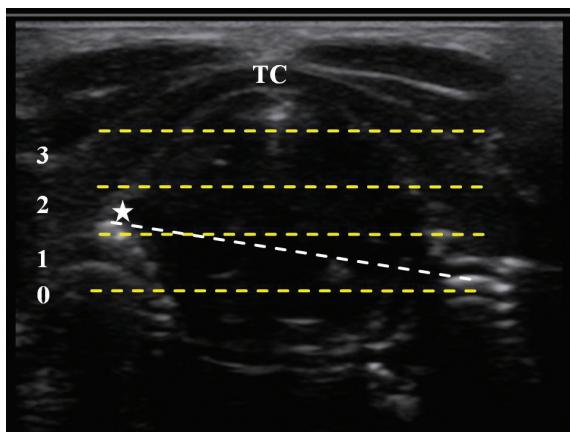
Transverse sonogram of the glottis. The asymmetrical elevation of an arytenoid cartilage was scored from 0 (bilateral symmetrical arytenoids) to 3 (in the upper one-third range of) in the reference to the dashed sections between the anterior and posterior commissures. The star* indicates the arytenoid elevation grade.
